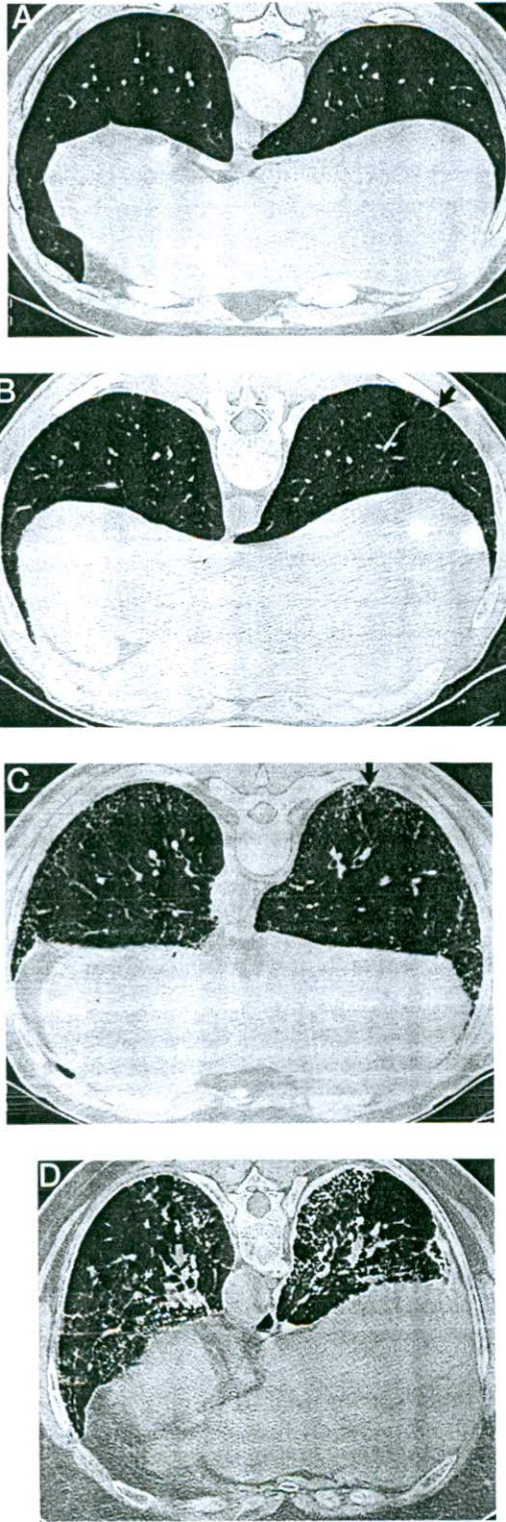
Typical HRCT scans through the lower lungs of HPS patients, showing progressively increasing scores. *Top, A*: no evidence of interstitial lung disease in a 27-year-old man (score = 0). *Top, B*: mild fibrosis (score = 1) in a 25-year-old man. Note thickened interlobular septum (arrow). *Bottom, C*: moderate fibrosis (score = 2) in a 53-year-old man. Note moderate peripheral reticulation (arrow). *Bottom, D*: severe fibrosis (score = 3) in a 53-year-old woman. Note reticular patches, bronchiectasis, peribronchovascular thickening (arrow), and subpleural cysts. See Materials and Methods for description of findings.
